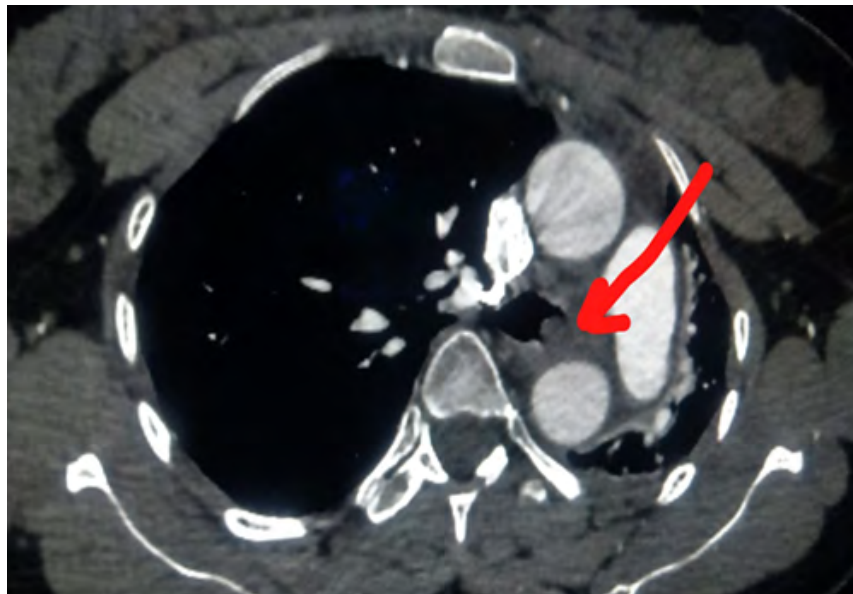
The right lung fields were clear with mild herniation across the midline. A subsequent contrast-enhanced computed tomography (CT) scan showed an intrabronchial mass obstructing the left lung.
